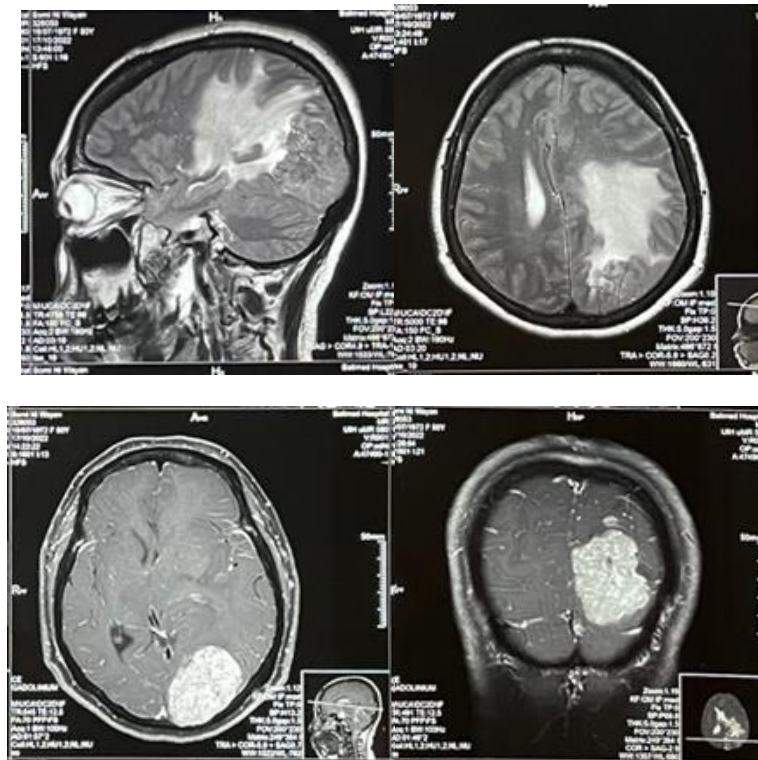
MRI showing large intracranial tumour consistent with meningioma
